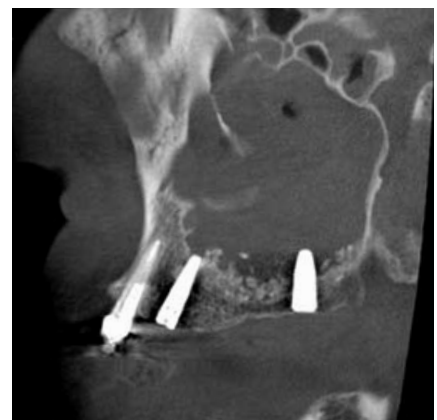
Sagittal CBCT image of the left maxillary sinus
